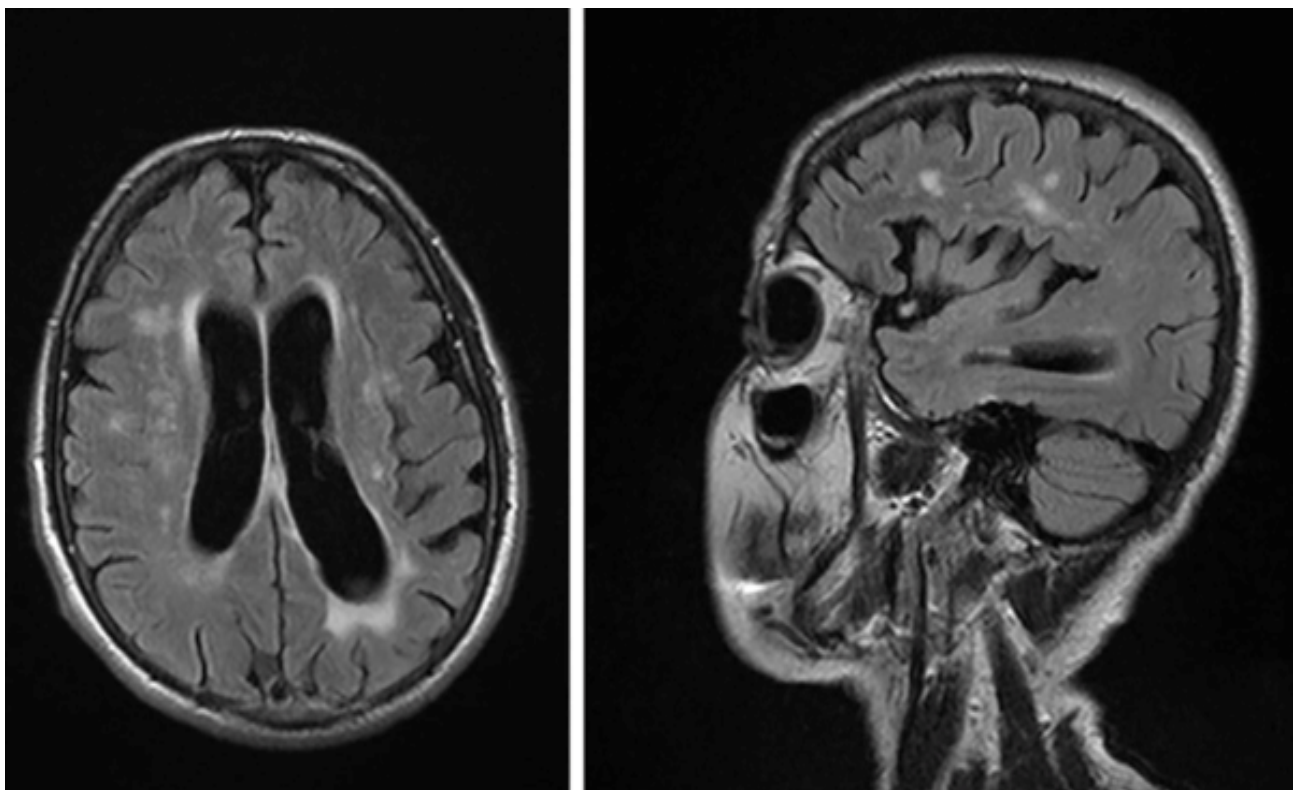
Sagittal and Axial FLAIR MRI sequence showing corticosubcortical atrophy.
